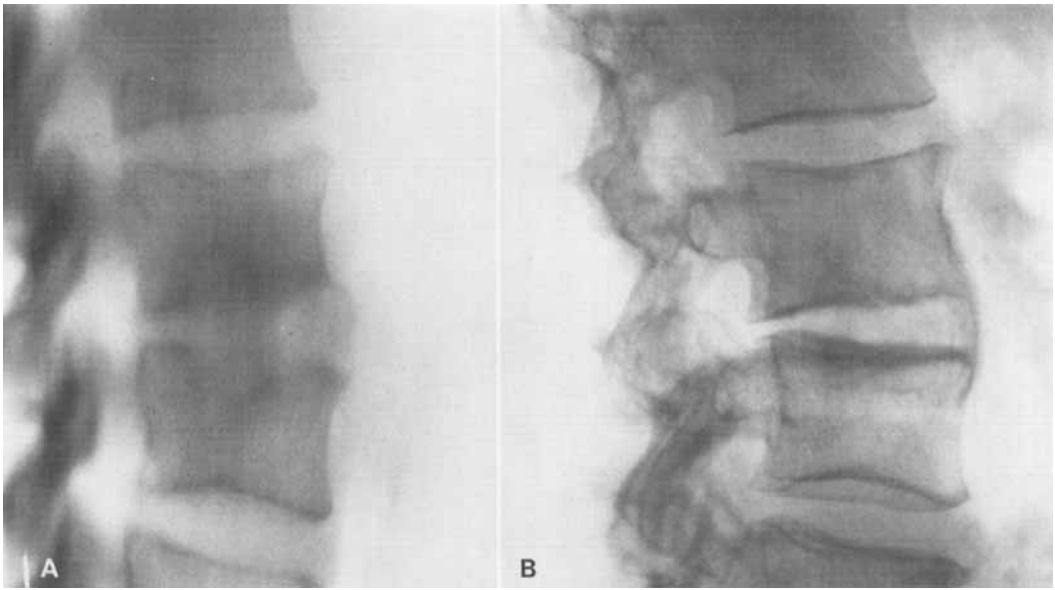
Radiographs of a male, 58 years of age. A. Tomogram 2.5 months after onset shows narrowing of the space between L2 and L3 and destruction in these vertebral bodies. No gibbus can be seen. A thin layer of new bone is visible anteriorly. B. Two years later the bone structure is partly normalized. Anteriorly there is a bridge of bone between L2 and L3.
